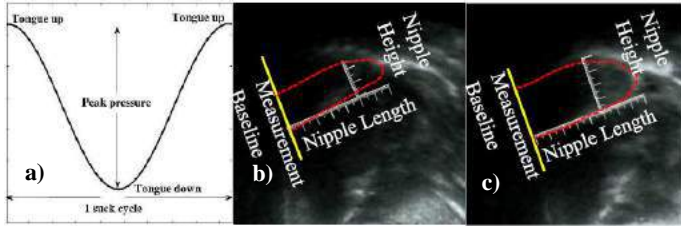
Nipple dimension measurement in ultrasound images. (a) Vacuum peaks when tongue moves down. (b) Tongue moving up (lowest vacuum). (c) Tongue moving down (strongest vacuum)
